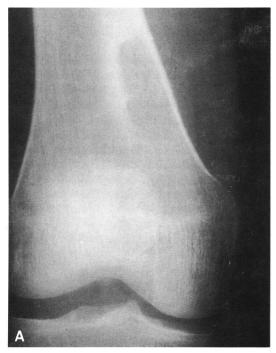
A: Anteroposterior roentgenogram of the left femur, including the area of the knee, shows an elongated, radiolucent, intra-cortical lesion at the metaphyseal area of the distal femur. B: Left lateral view reveals a surrounding sclerotic rim and non-mineralized matrix.
